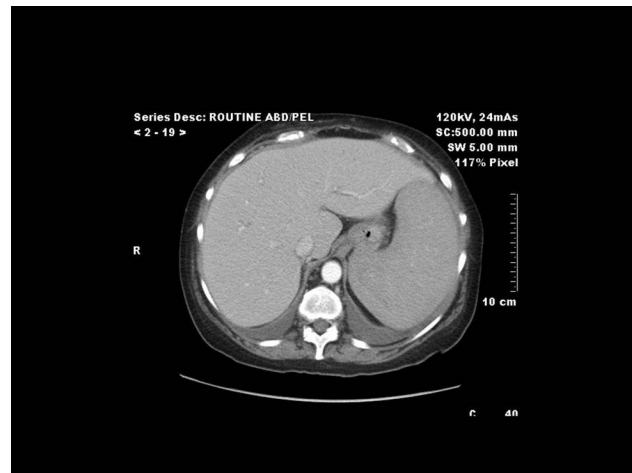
CT scan of the abdomen shows enlargement of the spleen, measuring 17.1 cm in greatest anteroposterior dimension. The spleen is heterogeneous with a hyperdense rim suggestive of new blood.
